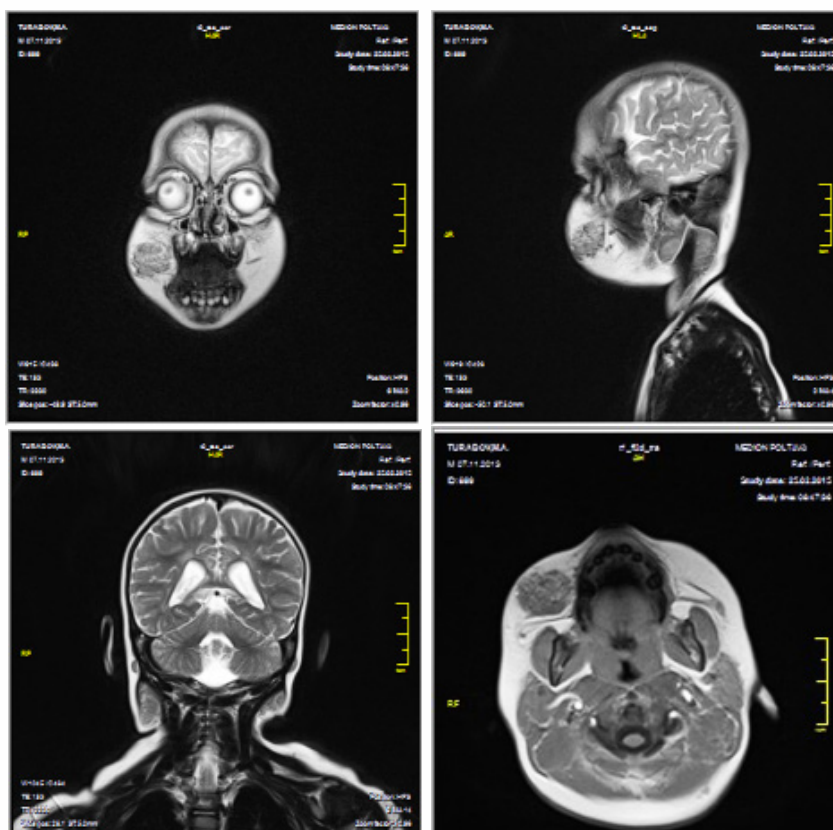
MRI-sections of a child with cavernous hemangioma of the left cheek
